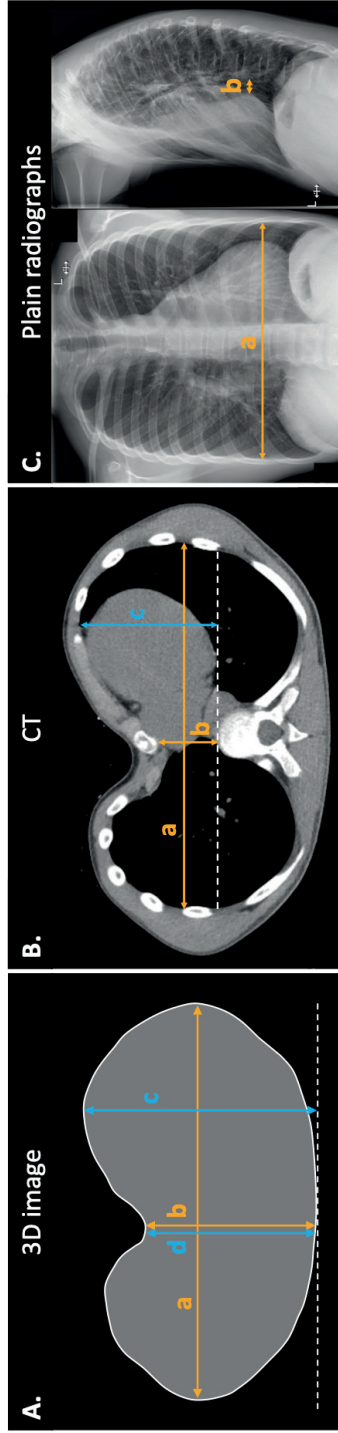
The measurement methods. (A) A transversal three-dimensional image slice that exhibits the most severe excavation and from which the external Haller index (a/b) and external correction index ((c-d)/c) are calculated. (B) A transversal CT image slice that like the three-dimensional image exhibits the most severe excavation and from which the conventional Haller index (a/b) and correction index ((c-b)/c) are calculated. (C) Two-view plain radiographs used to determine the conventional Haller index (a/b).
